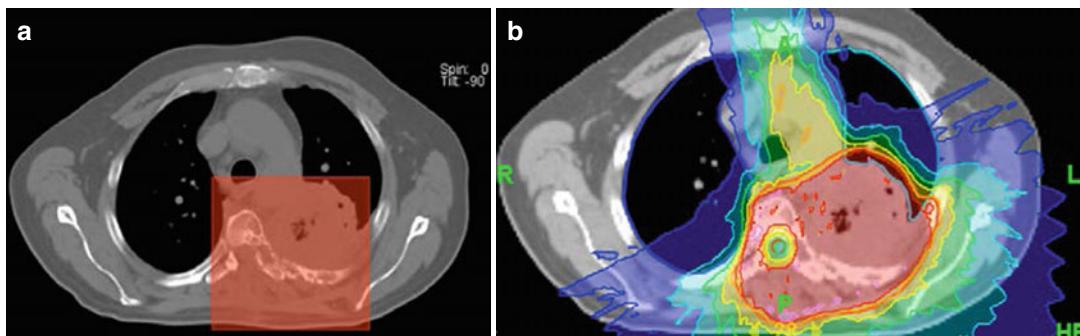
Presentation of a mass along the dorso-crinal thoracic wall left sided with infiltration of the paravertebral space, upper part of the thoracic spine and spinal canal in the planning CT (status post-laminectomy) (a). In
